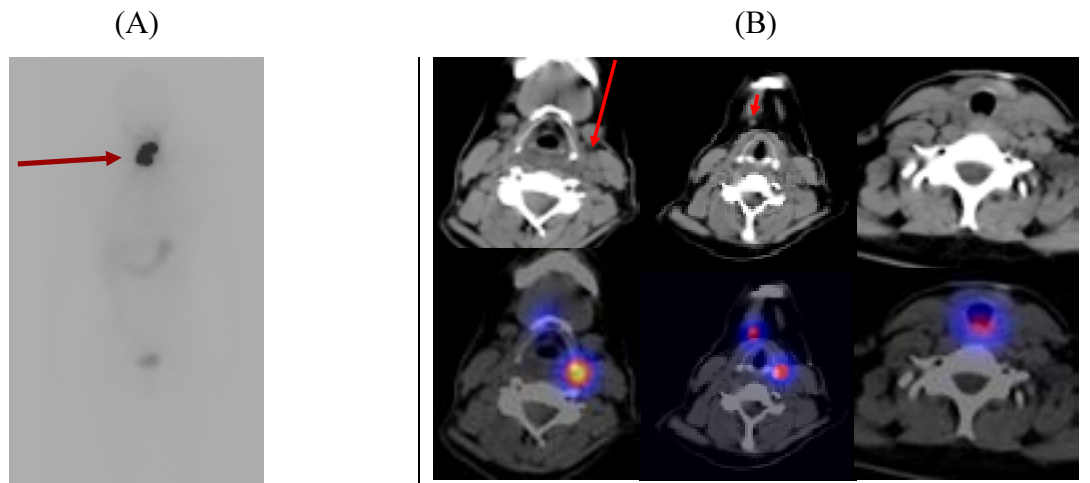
(A) The planar scan post-radioiodine ablation of thyroid remnants shows radioiodine-avid tissue in the neck of a patient after total thyroidectomy, without the possibility of discriminating ^{131}I uptake in remnant normal thyroid parenchyma from possible lymph node metastasis. (B) SPECT/CT demonstrates two cervical lymph nodes in this patient (arrows) that cannot be differentiated from benign remnant tissue in the planar scan.
